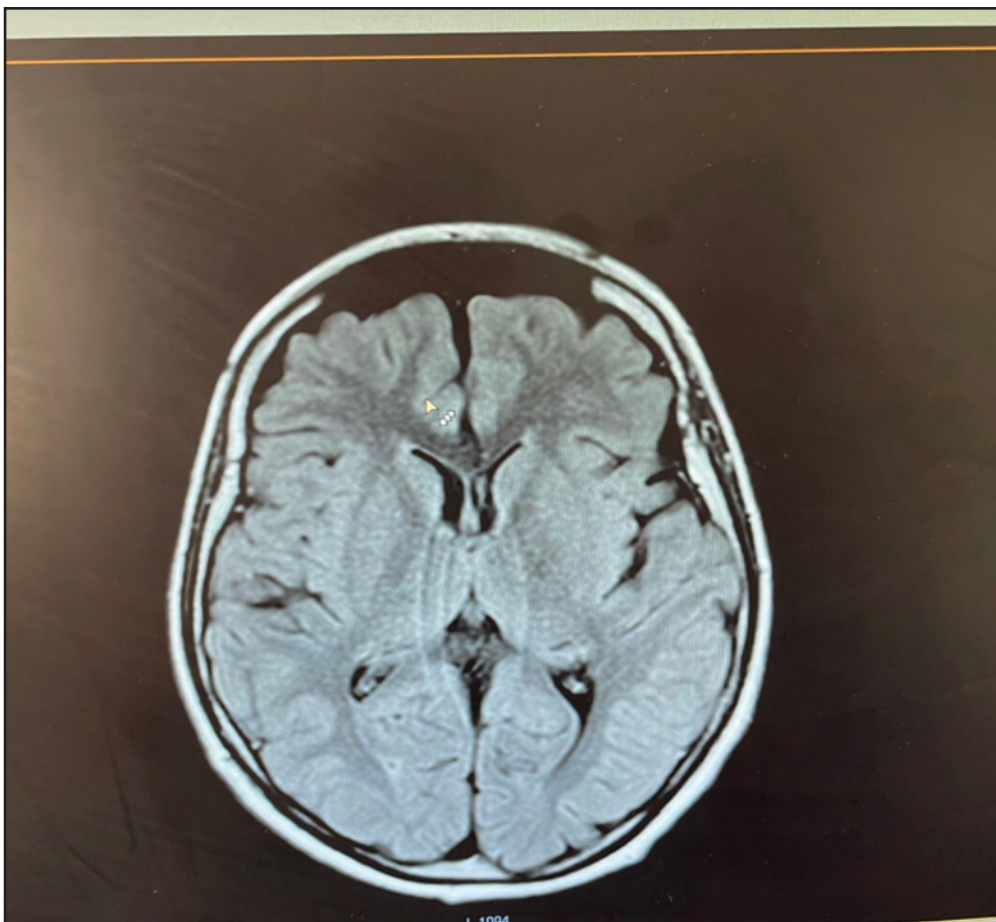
Brain MRI showing cortical atrophy
